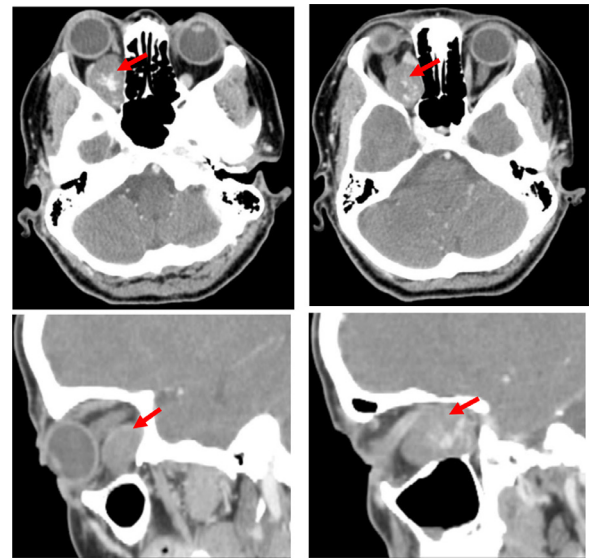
CT scan of the orbit showing a well-circumscribed right intraconical tissue process posterointernal in location (red arrow), with an intense enhancement and pushing back the optic nerve causing stage 2 exophthalmos.
